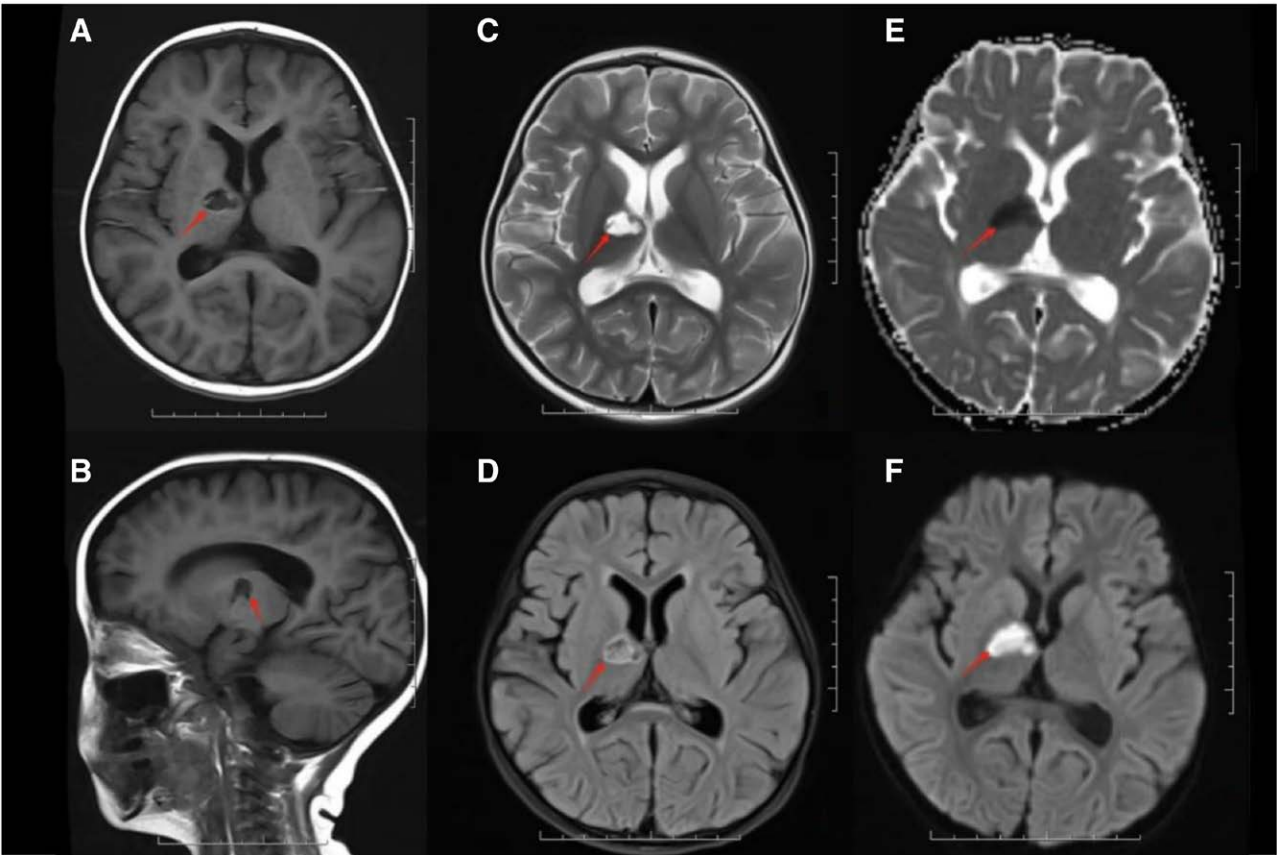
Abnormal cranial MRI findings in Case 1. A–C: Irregularly shaped T1-hyperintensity signals are observed in the right basal ganglia and thalamus. D: FLAIR showed hyperintensity signal. E,F: DWI showed hyperintensity signal, ADC showed hypointensity signal.
